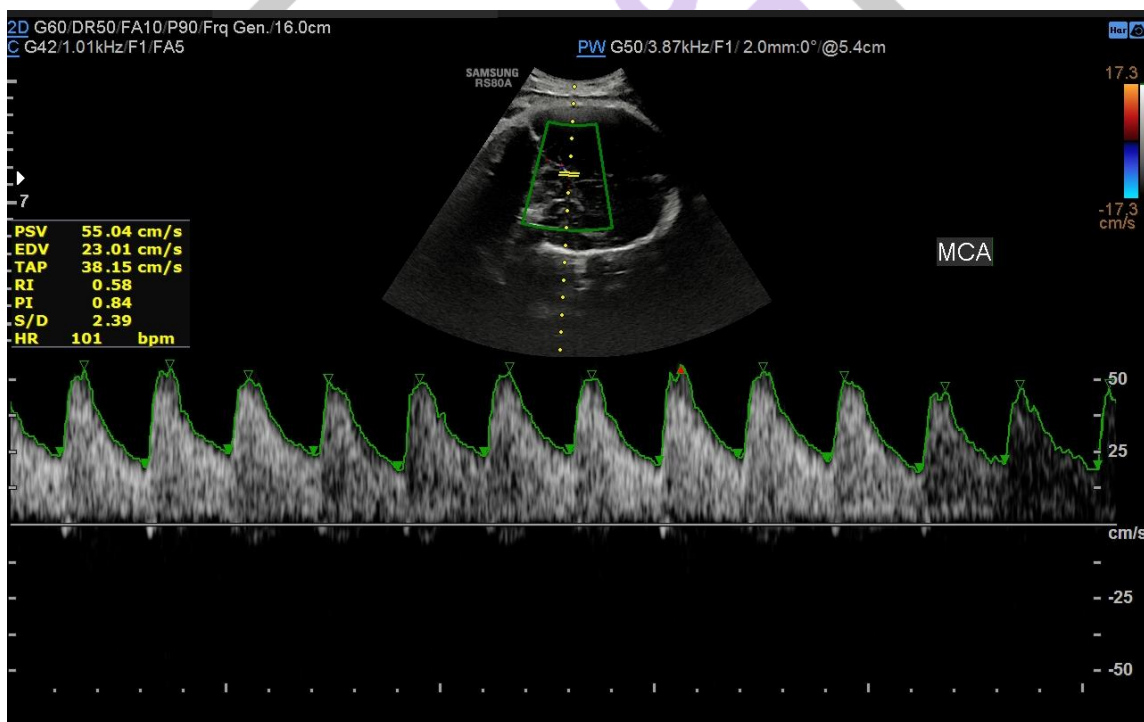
Abnormal middle cerebral artery doppler waveforms with decreased middle cerebral artery pulsatility index (PI) and resistivity index (RI).
